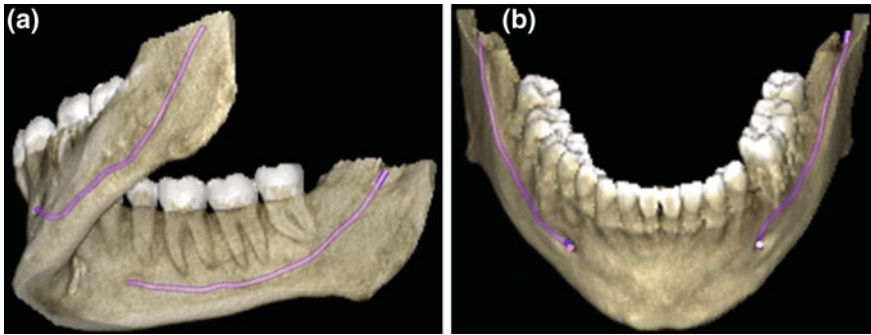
a, b Inferior alveolar nerve's course in the mandibular canal: 3D-CBCT reconstruction. Its relationship with dental roots could easily be seen
